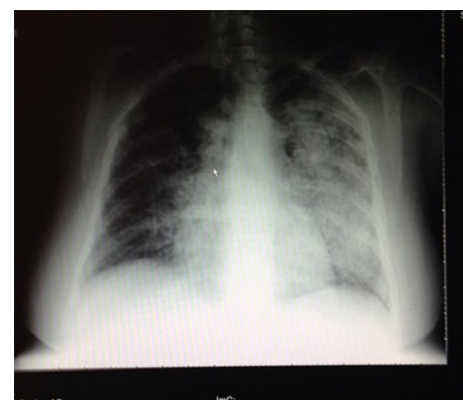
Chest x-ray on the third day of admission showed alveolar opacity in the left lower lobe.
